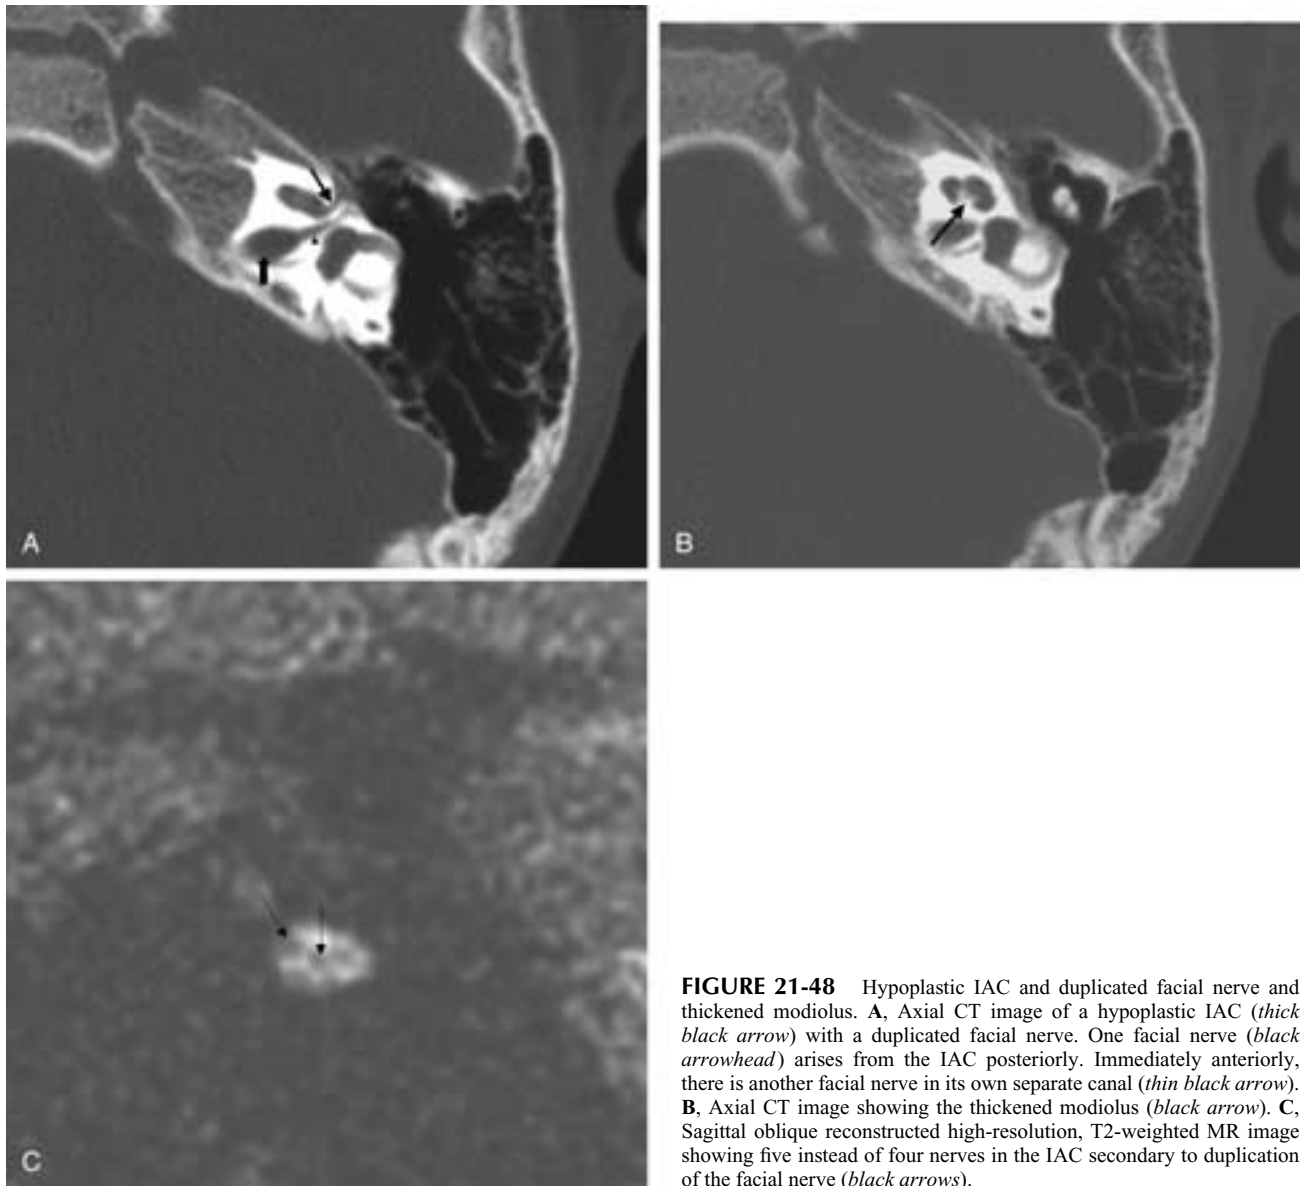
Hypoplastic IAC and duplicated facial nerve and thickened modiolus. A, Axial CT image of a hypoplastic IAC (*thick black arrow*) with a duplicated facial nerve. One facial nerve (*black arrowhead*) arises from the IAC posteriorly. Immediately anteriorly, there is another facial nerve in its own separate canal (*thin black arrow*). B, Axial CT image showing the thickened modiolus (*black arrow*). C, Sagittal oblique reconstructed high-resolution, T2-weighted MR image showing five instead of four nerves in the IAC secondary to duplication of the facial nerve (*black arrows*).
